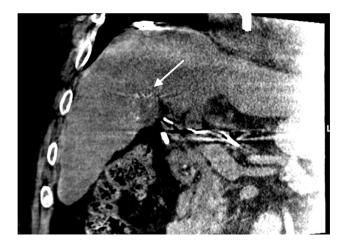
C-arm CT image using gadolinium contrast after chemoembolization with the white arrow demonstrating static contrast in the tumor periphery.
